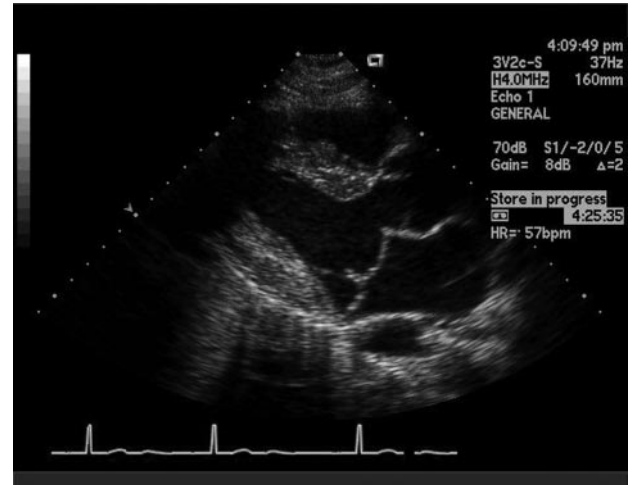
Transthoracic echocardiogram of a patient with Marfan syndrome with mitral valve prolapse and 4-cm ascending aortic aneurysm.
